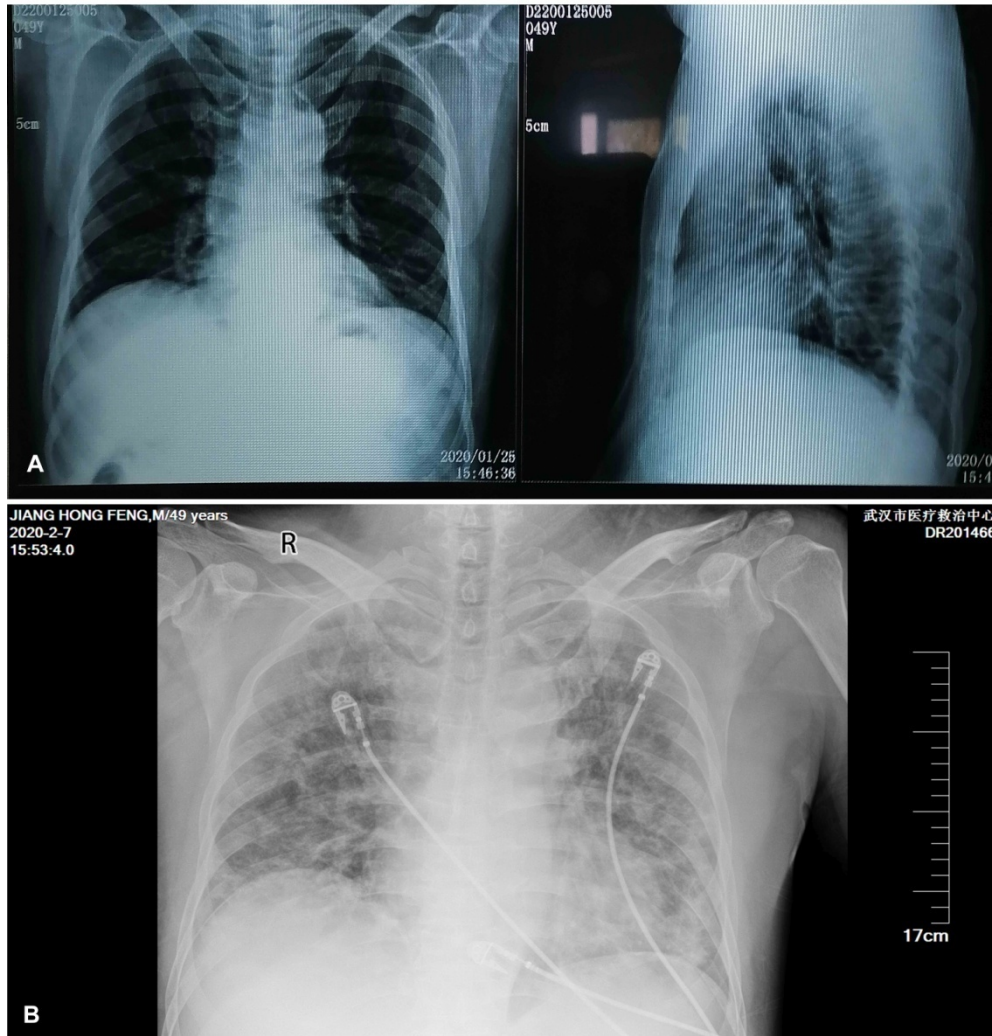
Chest Radiographs of patient. A. Posteroanterior and Lateral Chest Radiographs, January 25, 2020. B. Posteroanterior Chest Radiographs, February 7, 2020
